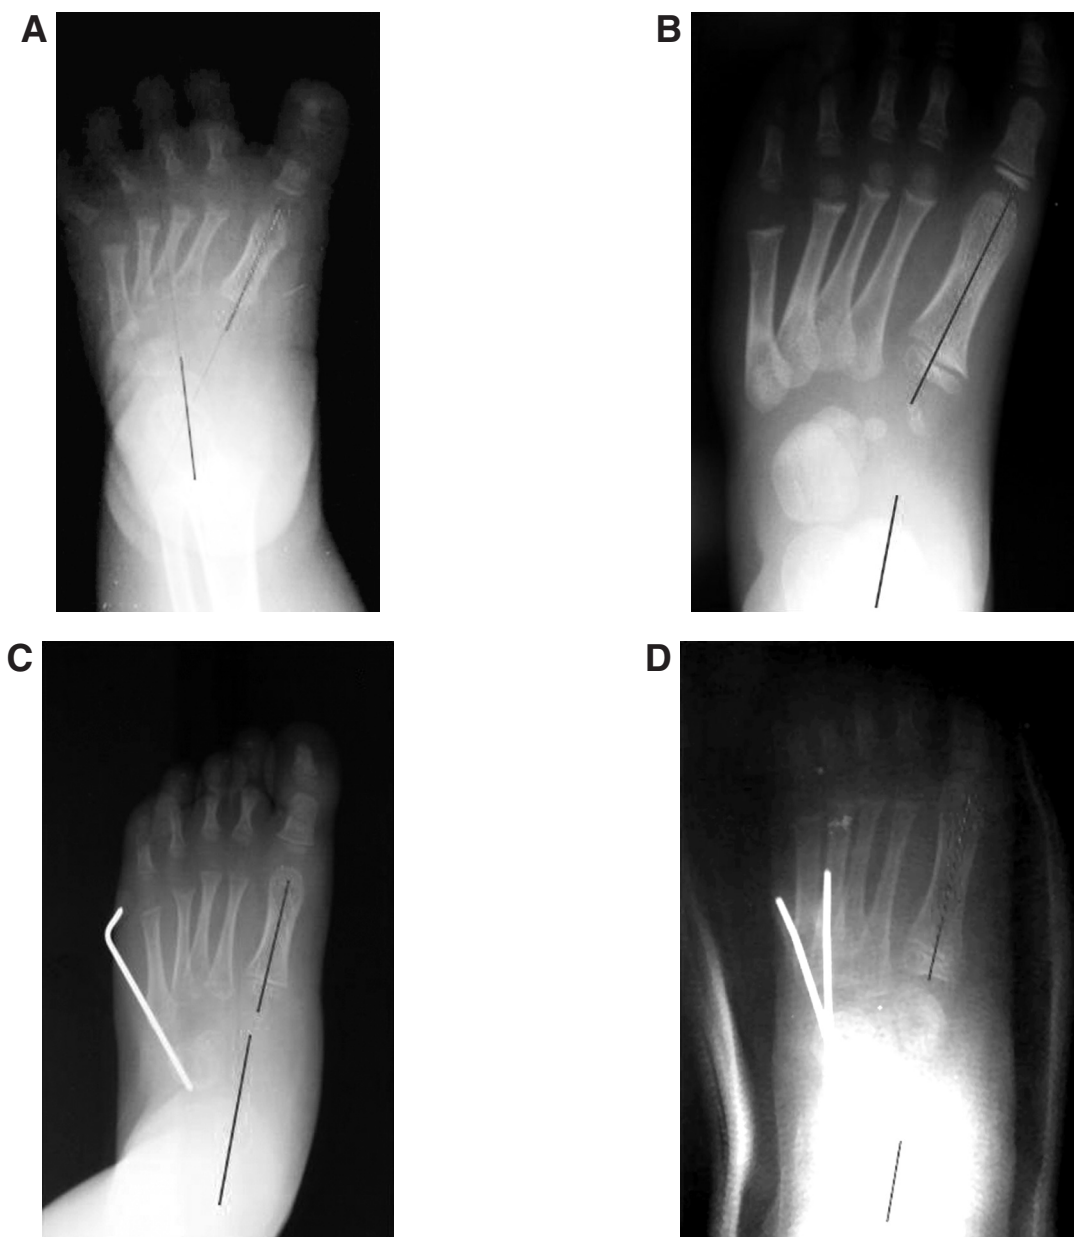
Preoperative (A and B) and postoperative (C and D) radiographs showing the reduction in forefoot adductus in two different left feet.
